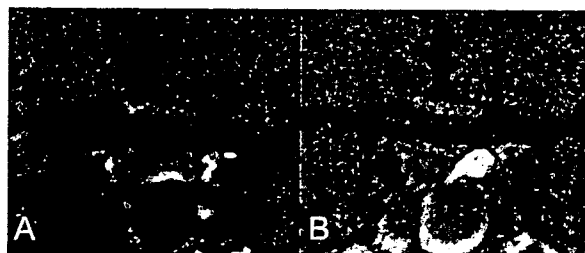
(A) Preoperative head MRI. No apparent microadenoma was shown in the sella. (B) Postoperative head MRI. Fat tissue was replaced at the resected cavity.
